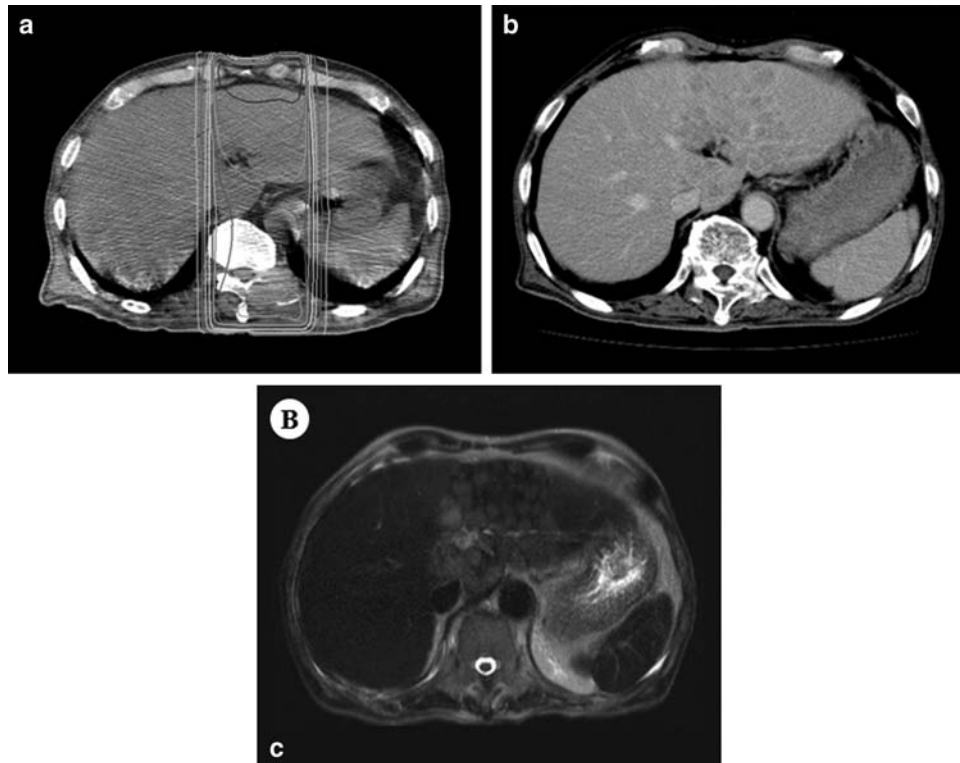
A CT slice showing isodose lines of irradiation (A). A well-defined, poorly enhanced lesion is visualised in the liver corresponding to the irradiated area (B). The lesion is visualised as an aggregation of nodules on MRI (C).
